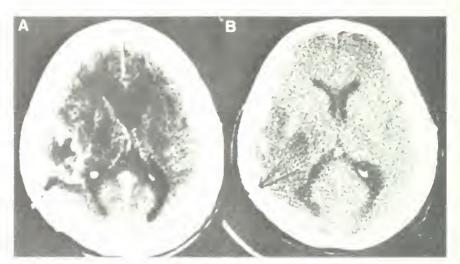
CT scan A is of a Glbm in the right hemisphere of patient #19 immediately before ultrasound therapy was started four months after first symptoms. During the prior four months he had had two surgeries and radiation therapy. B, taken six months after chemotherapy augmented by ultrasound was started. Headache, vomiting, lethargy, left hemiparesis and papilledema had subsided. He is still living more than 60 weeks after his second surgery for what appeared to be a very rapidly growing neoplasm. His Karnofsky rating is between 070 and 080.
